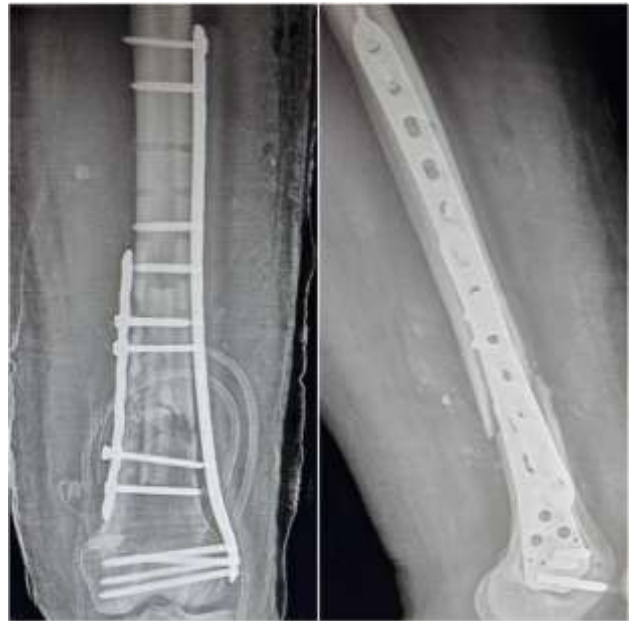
Immediate post-operative X-ray after revision surgery.
